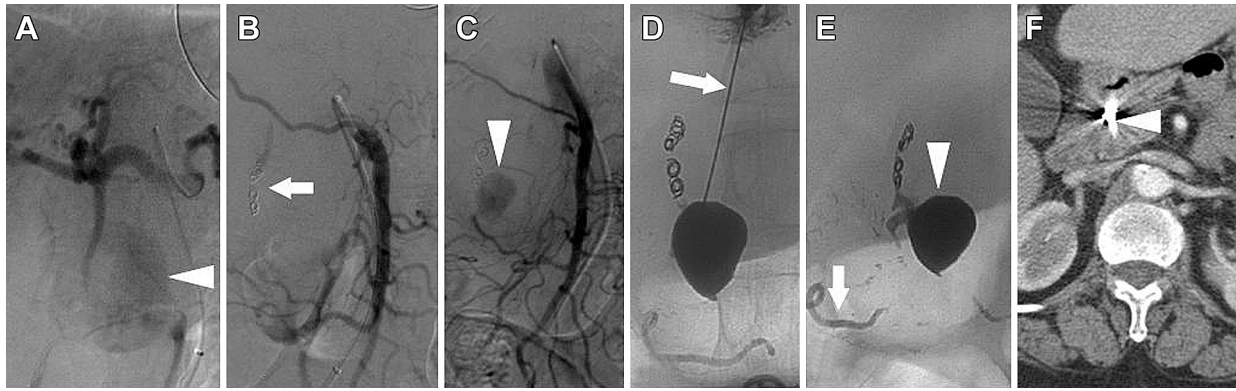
A 73-year-old female with acute pancreatitis presented with acute pain abdomen. (A) Digital subtraction angiography shows the pseudoaneurysm (arrowhead) arising from the gastroduodenal artery (GDA). (B) Coil embolization of GDA (arrow). (C) However, pseudoaneurysm reperfused through multiple small distal feeders from the pancreaticoduodenal arcade (arrowhead). (D) As these feeders were not accessible, percutaneous direct injection of *N*-butyl cyanoacrylate into the pseudoaneurysm was done under ultrasound guidance using a Chiba needle (D, arrow). (E) Note the reflux of glue into the distal feeders (arrow). (F) Follow-up computed tomography 10 months later showing no reperfusion of the pseudoaneurysm (arrowhead).
